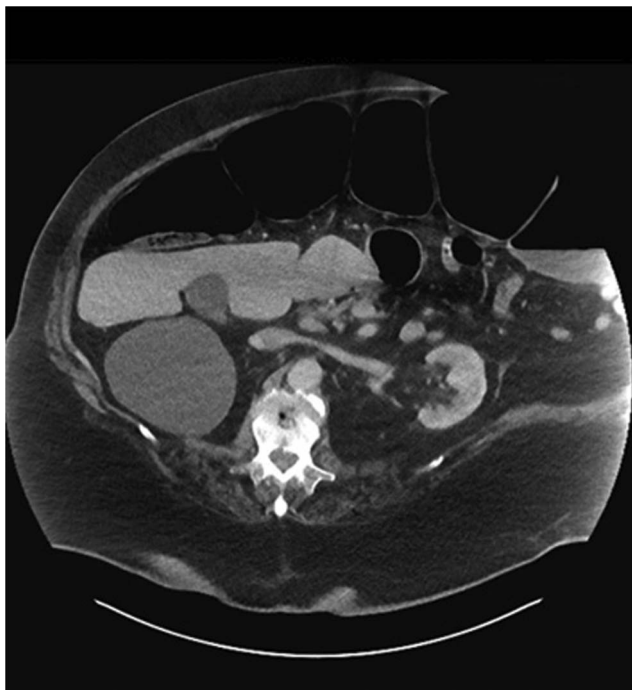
Abdominal-pelvic computed tomography scan showing colonic distension.
